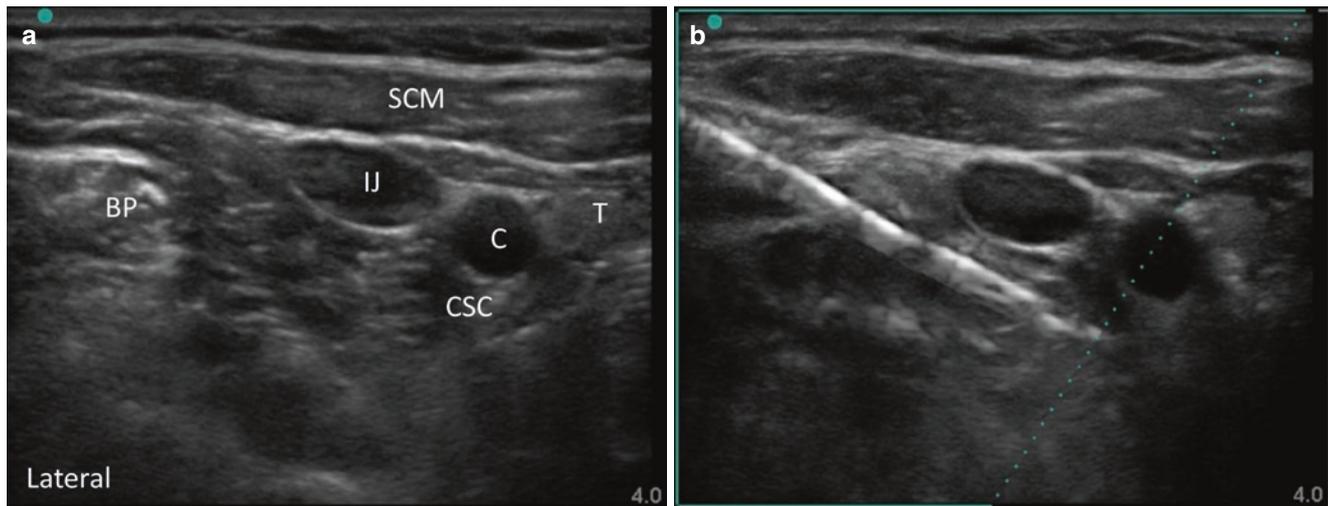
Ultrasound-guided stellate ganglion block (lateral approach). (a) Transverse ultrasound view at the level of the cricoid cartilage demonstrating the brachial plexus (BP), sternocleidomastoid (SCM), thyroid (T), internal jugular (IJ) vein, carotid artery (C), and cervical
